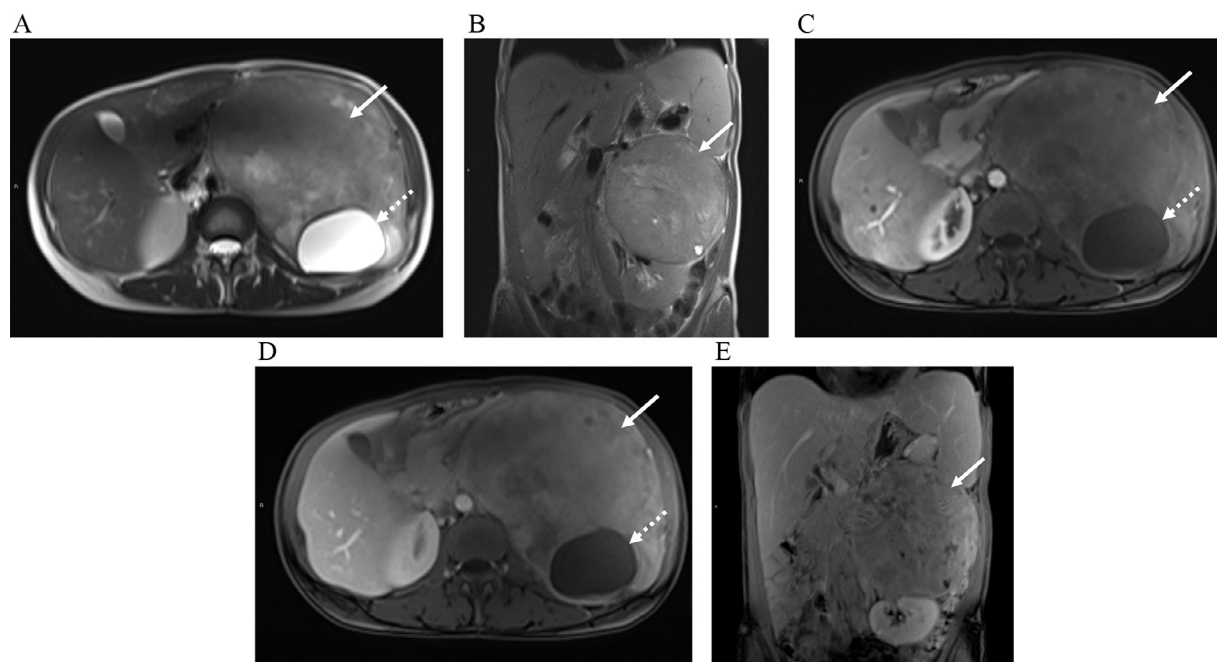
Axial (A) and coronal (B) T2-weighted MR images show a large well-circumscribed left suprarenal mass (arrows) with heterogeneous T2 signal intensity and internal cystic component (dotted arrow). Axial IV contrast-enhanced T1-weighted fat suppressed MR images in the arterial (C) and venous phase (D) and coronal IV contrast-enhanced T1-weighted fat suppressed MR image with a 5-minute delay show progressive heterogeneous enhancement in the large suprarenal mass (arrows). No internal enhancement within the cystic component (dotted arrows).
